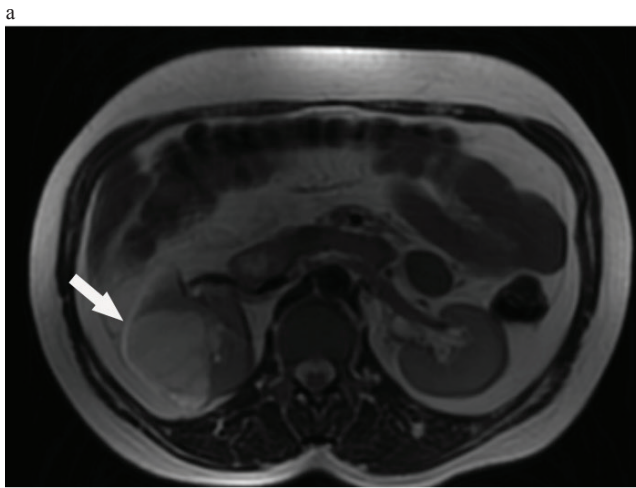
A renal cyst (white arrow) in the right kidney appears hyperintense on T2-weighted image (figure 1a). The cyst has an ADC value of $2.72 \times 10^{-3} \text{ mm}^2/\text{s}$ and an Fa value of 0.16. Figure parts 1b and 1c are ADC and Fa maps, respectively.
